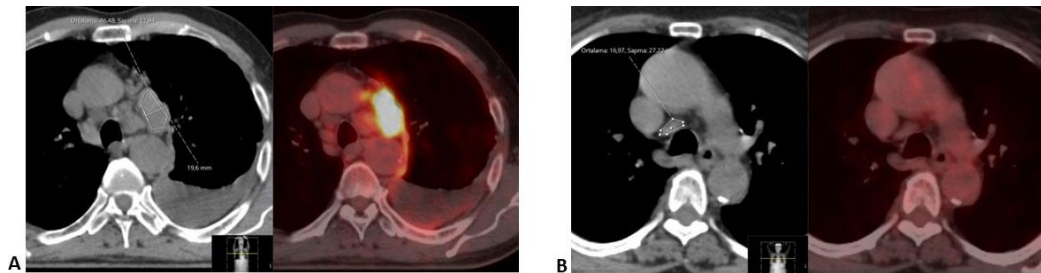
Density measurement with ROI circle in non-contrast CT base images of PET + LN in the aorticopulmonary window (A) and PET - LN in the right parathecal (B)
